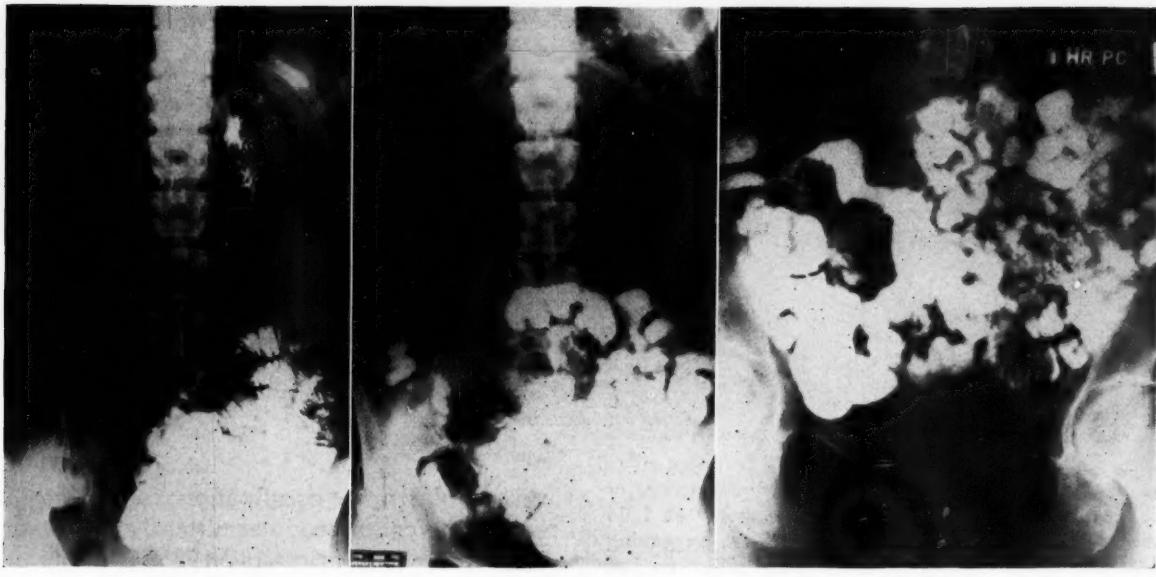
A, x-ray four and one-half hours after plain barium meal; motility was delayed but the pattern was normal; B, three-quarters of an hour after introduction of milk the pattern was distorted by segmentation, pooling and narrowing or dilatation of the loops; C, one hour after milk there were similar but more advanced alterations.
